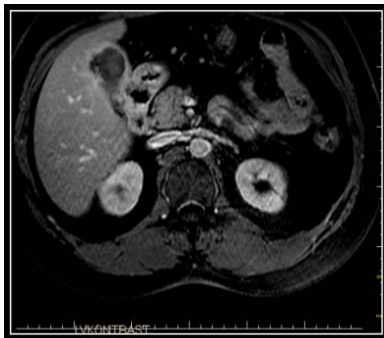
Axial contrast MR Imaging demonstrates ill-defined enhancement at gadolinium-enhanced MR imaging is an appearance of these tumors.
